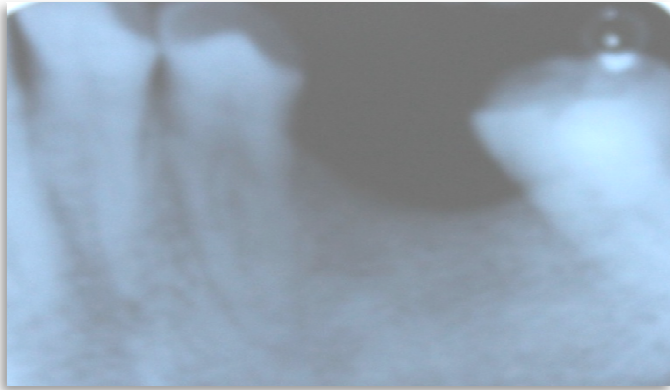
Periapical radiograph of #45 attrition with mild periapical radiolucency
